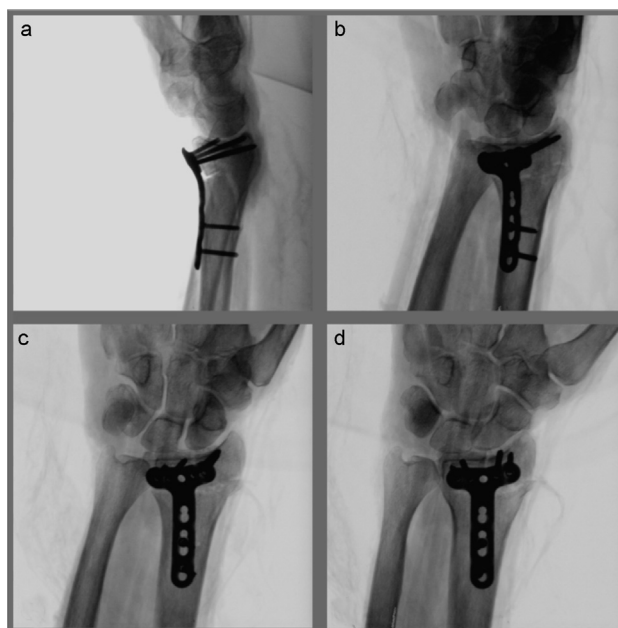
a–d: four 3D-fluoroscopy images of a series of 110 images, showing distal radius LCP osteosynthesis. The image quality was rated to be very good. In this case, intraarticular screw cutting out of the medial radial screw (arrow) was suspected in X-ray. The oblique projections helped to identify the extraarticular screw position that was confirmed with computed tomography.
